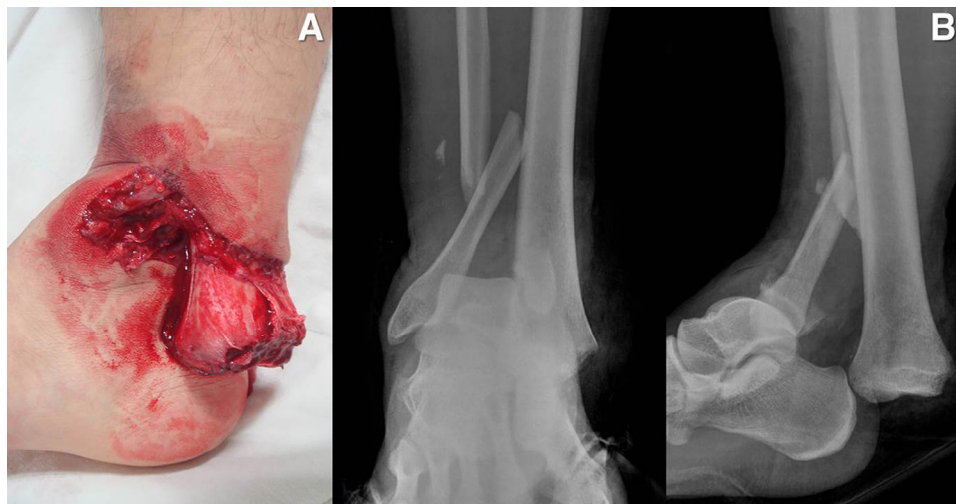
(A) Photograph of an open ankle fracture dislocation after a motorcycle accident. (B) Preoperative anteroposterior and lateral radiographs at the emergency room.
